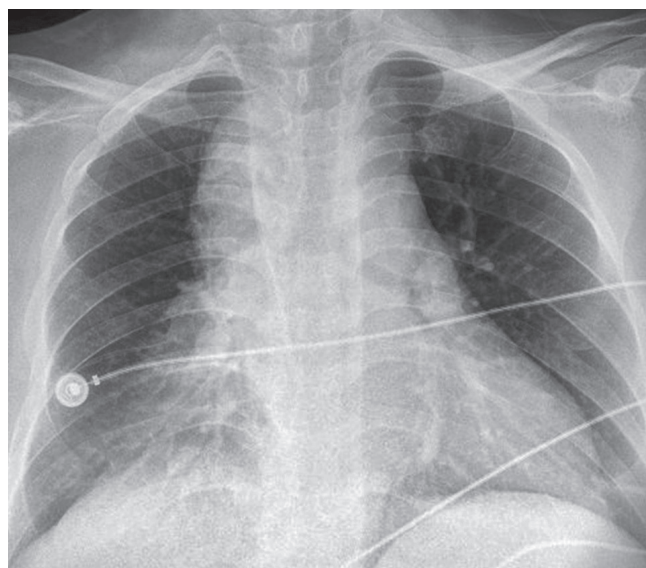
Representative initial chest radiography with mediastinal widening.
